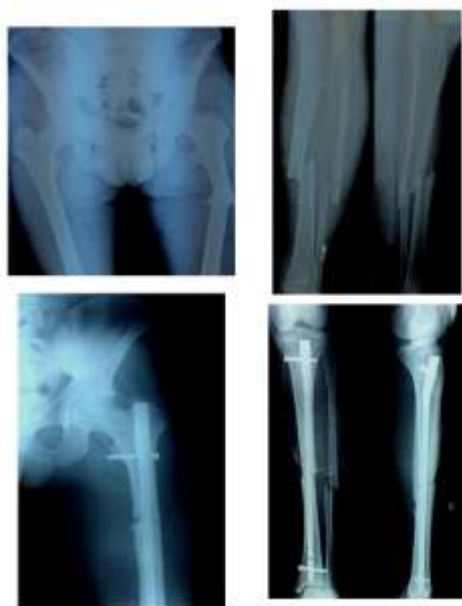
Fraser Type I floating knee, left lower limb. Top: preoperative radiographs showing ipsilateral femoral and tibial diaphyseal fractures. Bottom: postoperative radiographs
